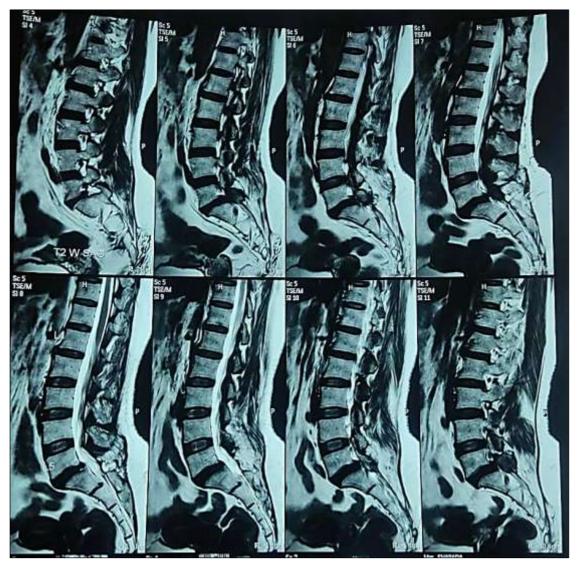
MRI of L-S Spine with IVDP at L5-S1 (T2 weighted)
